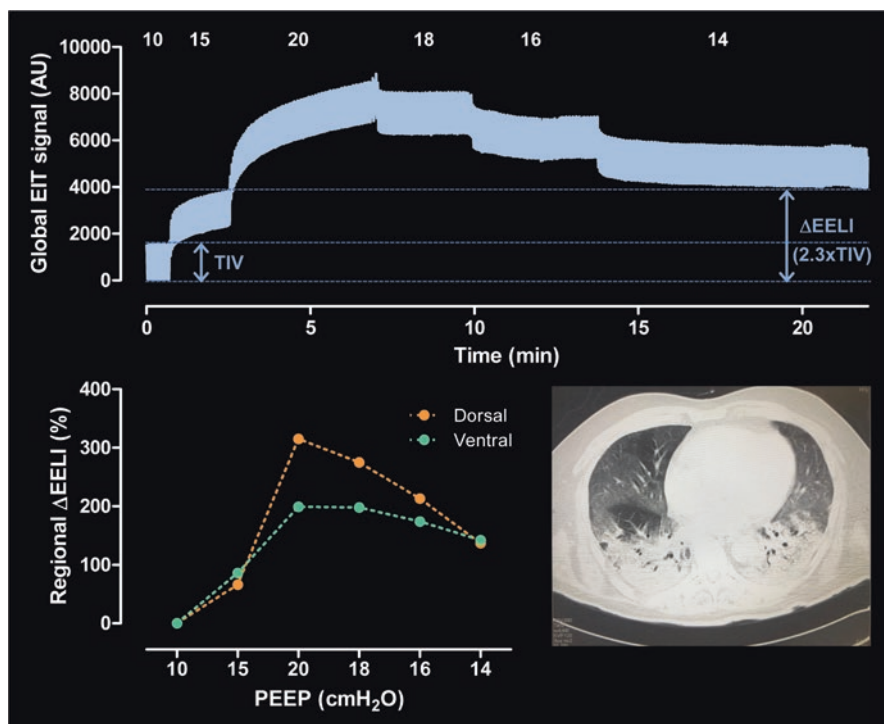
A global (i.e., whole image) EIT signal waveform in arbitrary units (AU) acquired in a supine 64-year-old man suffering from COVID-19-related ARDS during two incremental and four decremental steps in positive end-expiratory pressure (PEEP) (*top*). The EIT examination took place on the second day of ICU admission. The blue arrows show the amplitude of tidal impedance variation (TIV) during ventilation at the initial PEEP value and the change in end-expiratory lung impedance (ΔEELI) at the last PEEP value compared with the beginning of the maneuver. The numbers above the waveform present the set PEEP values in cmH₂O. The ΔEELI values in the ventral and dorsal lung regions relative to the initial values at the lowest PEEP (*bottom left*) demonstrate the more pronounced increase in the dependent regions, implying recruitment. Chest CT scan (*bottom right*) was obtained on the first day of ICU admission. (Reproduced from [2])
